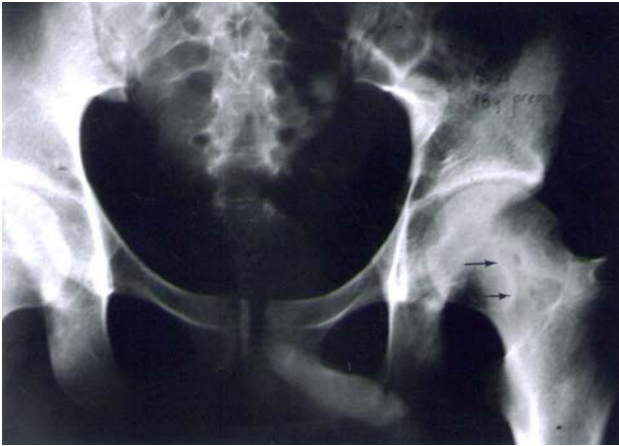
The anteroposterior radiograph of pelvis (hip) showing the presence of two discrete radiolucent foci of osteoid osteoma in left femoral neck
